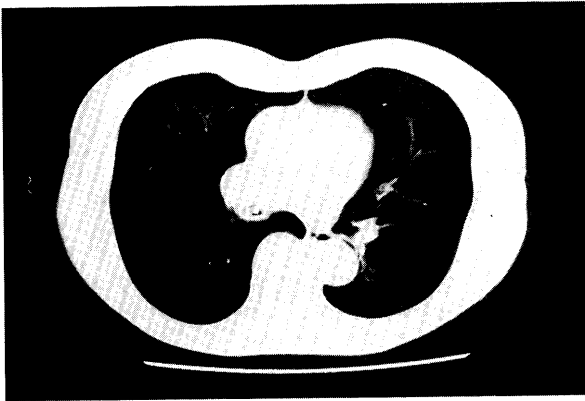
CT scan of the thorax shows an intrabronchial round opacity with calcification in the right intermedium bronchus.
